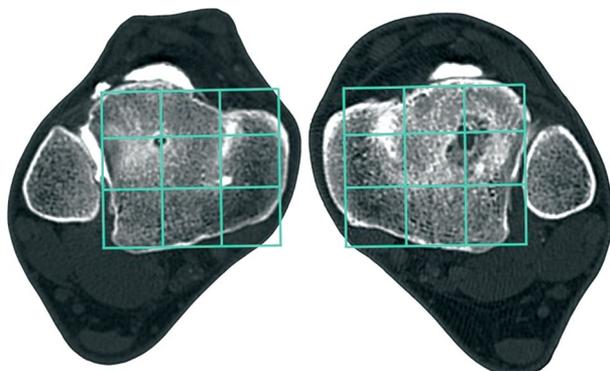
Axial computed tomography image of distal tibiae. Demonstration of symmetrical bilateral lesion with different sizes.
